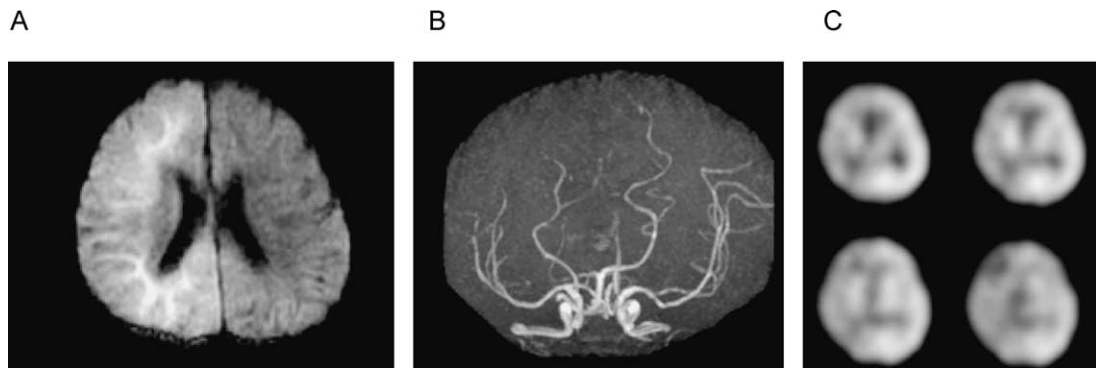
(A) Diffusion-weighted magnetic resonance image on the 6th day of the illness showing high intensity in the right cerebral hemisphere. (B) Magnetic resonance angiography on the 6th day of the illness showing a narrow flow signal in the right distal cerebral artery. (C) Single photon emission computed tomography on the 9th day of the illness showing hypoperfusion of the right cerebral hemisphere.
